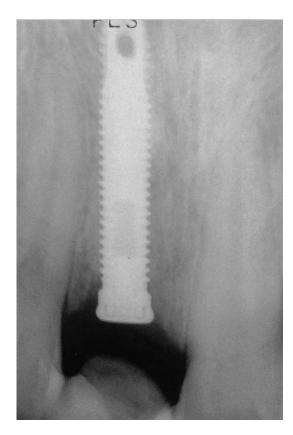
Radiographic images immediately after implantation and 6 months after extraction and bone grafting.
